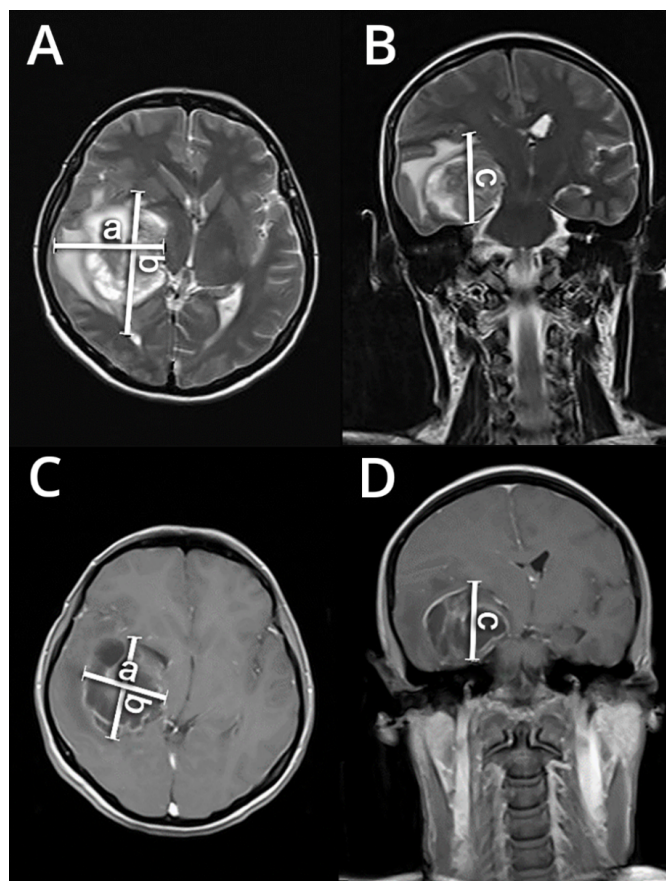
MRI-based radiomorphometric assessment of glioblastoma and peritumoral brain oedema: A) Axial measurement of two orthogonal diameters of the combined tumour-plus-oedema region, B) Sagittal measurement of the combined tumour-plus-oedema region, C) Axial measurement of two orthogonal tumour diameters, D) Sagittal measurement of tumour diameter
